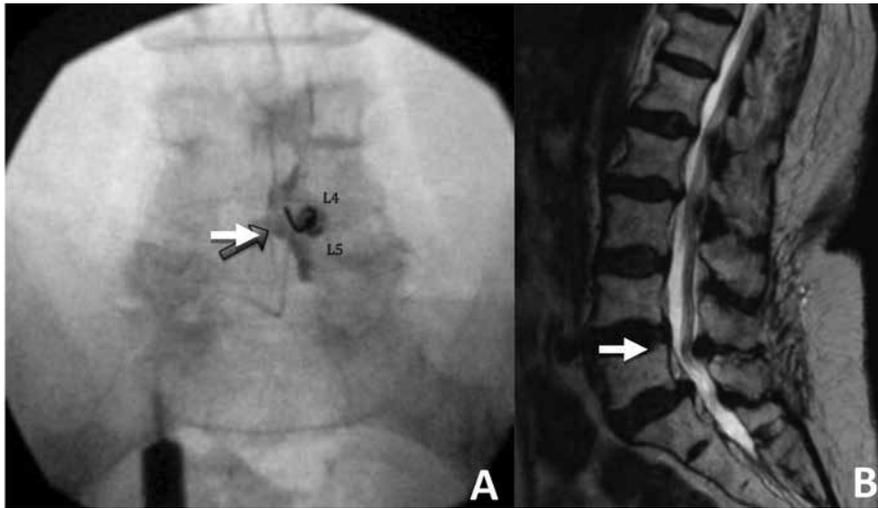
(A) Intraoperative fluoroscopic imaging depicting epidural contrast medium spread (arrow) at the L4/5 level. (B) T2-weighted MRI imaging of the lumbar spine in the sagittal plane after interlaminar epidural injection demonstrating no evidence of an epidural collection.
